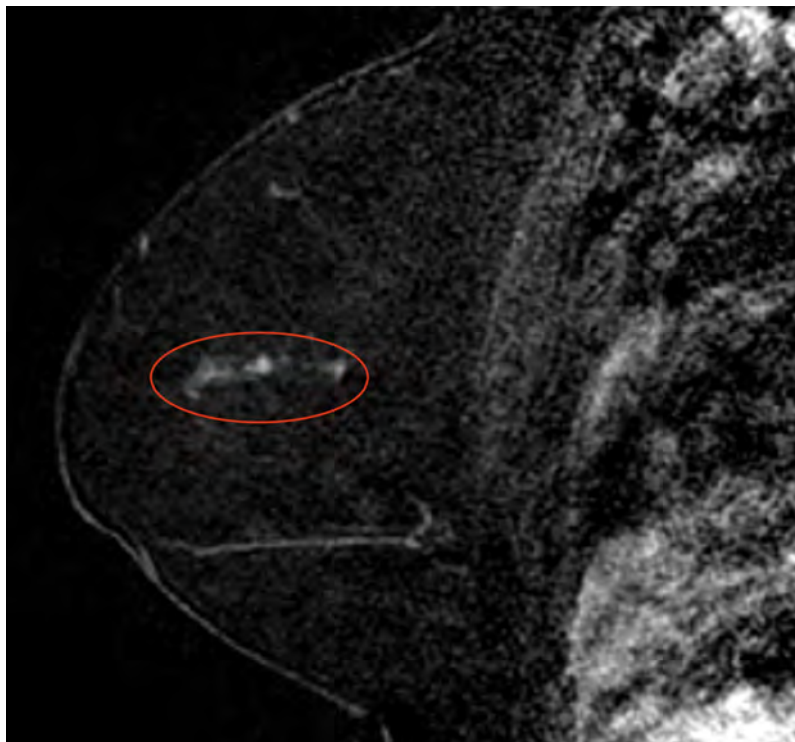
Sagittal T1-weighted, contrast-enhanced subtraction MRI of the right breast demonstrates linear clumped nonmass enhancement in the right central breast at middle depth (oval). This abnormal enhancement initiates at the site of duct cut-off seen on galactogram (A), and biopsy was performed under MRI guidance. Pathology yielded papillary DCIS.
